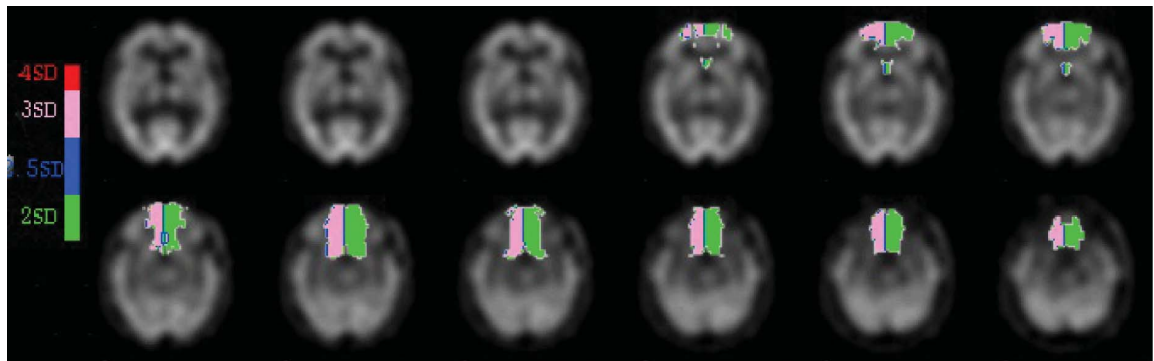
Quantified Tc-99m-ECD SPECT perfusion scan of the brain at 7 days post-stroke demonstrating a significant decrease of perfusion in the left ($z = -2.18$; $p = .02$) and the right ($z = -3.83$; $p = .00$) inferior medial frontal regions.
